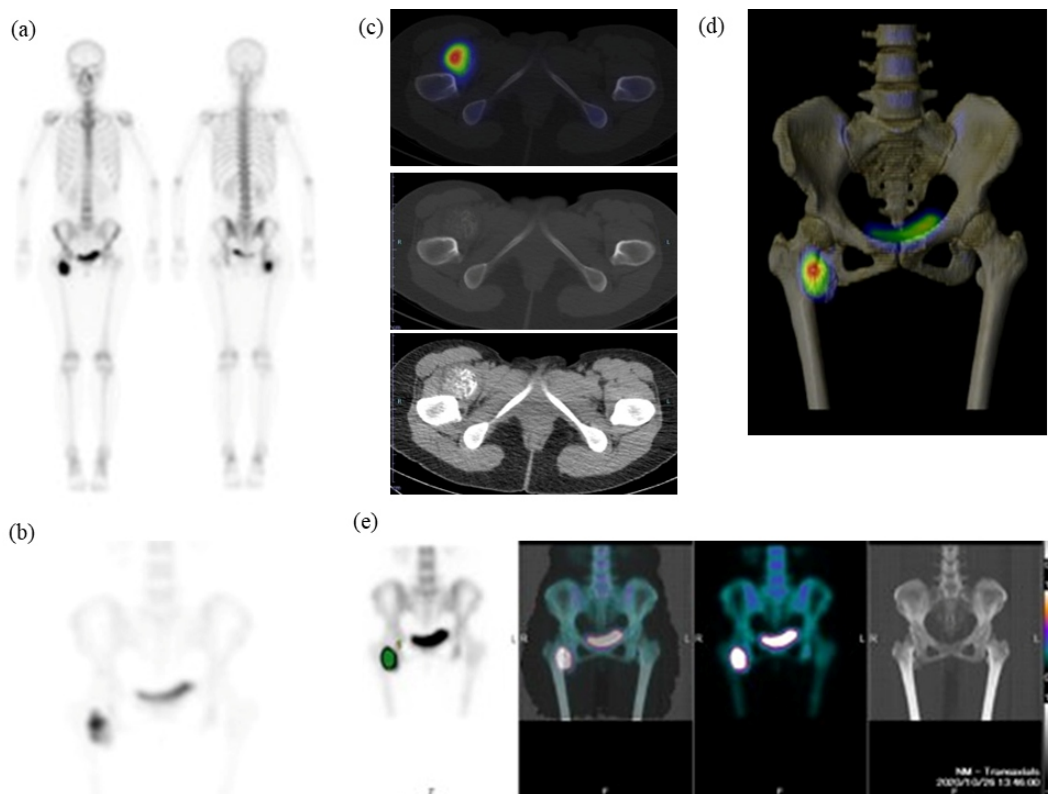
Representative patient; woman (31 years old) with heterotopic ossification of the right quadriceps. a) Planar bone scintigraphy, b) spot planar view, c) transaxial bone SPECT/CT, and d) 3D-SPECT/CT showing strong uptake and heterotopic ossification in the right quadriceps. e) VOI indicated by the GI-BONE® software package and calculated quantitative values are shown below the images: SUVmax 44.35, SUVpeak 40.53, SUVmean 26.05, MBV 19.74, and TBU 514.16. Based on the relatively high metabolic activity, drug treatment (bisphosphonates) was performed.
